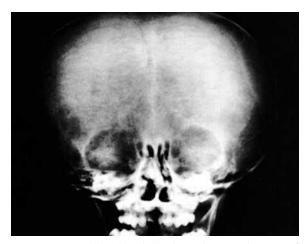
Macrocephaly. Plain skull radiographs allow detection of primary skeletal dysplasias. In this case, note the mosaic rarification of the cranial vault and multiple wormian bones characteristic of osteogenesis imperfecta. (*Courtesy Department of Radiology, Children's Hospital of Pittsburgh, Pittsburgh, Pa.*)
